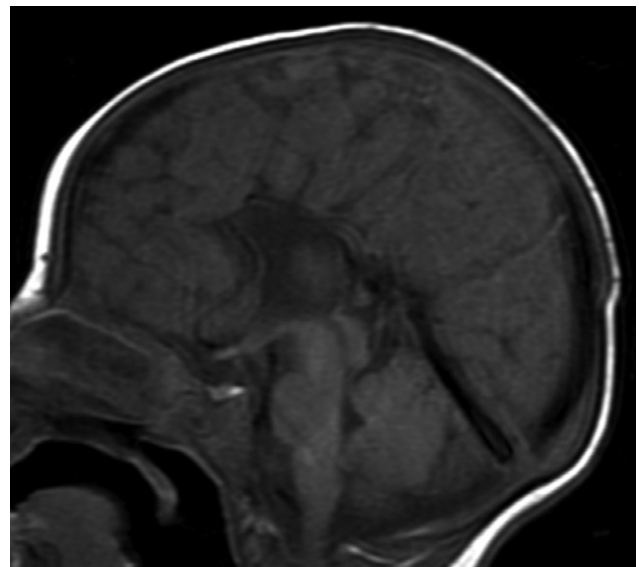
Neuroimaging. Sagittal T1-weighted MR image of the brain showing agenesis of the corpus callosum.
